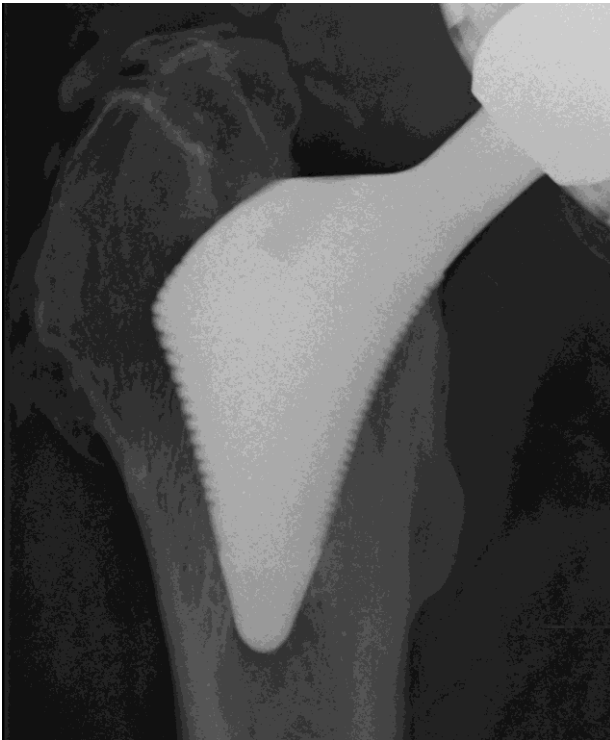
Two-years postoperative X-ray image
